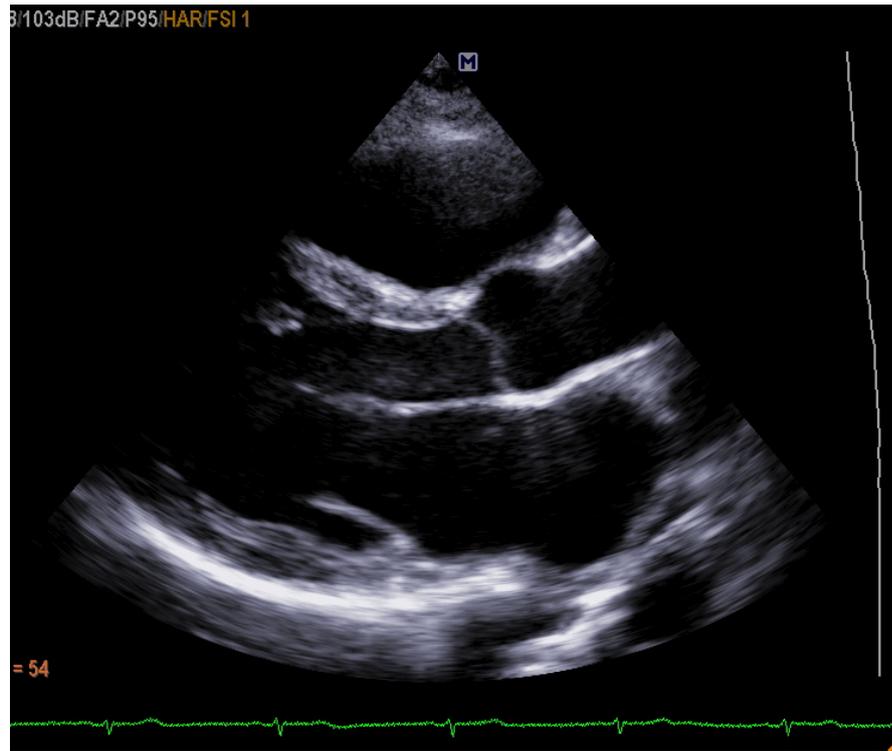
Parasternal long-axis view
